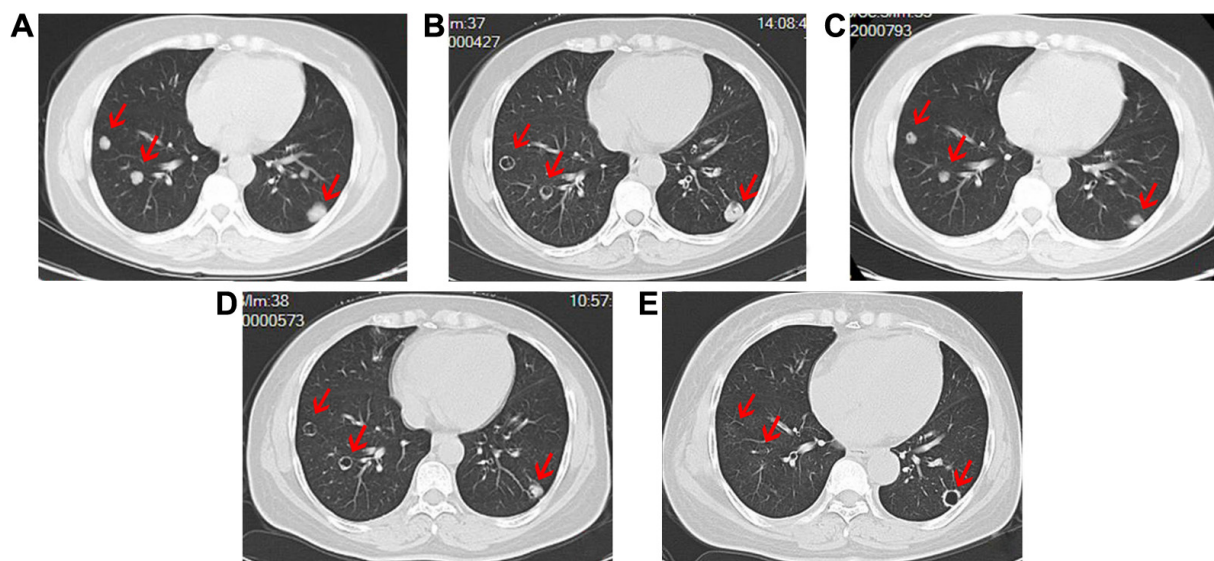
Computed tomography images of the chest of a patient with multiple lung metastases from renal leiomyosarcoma.
